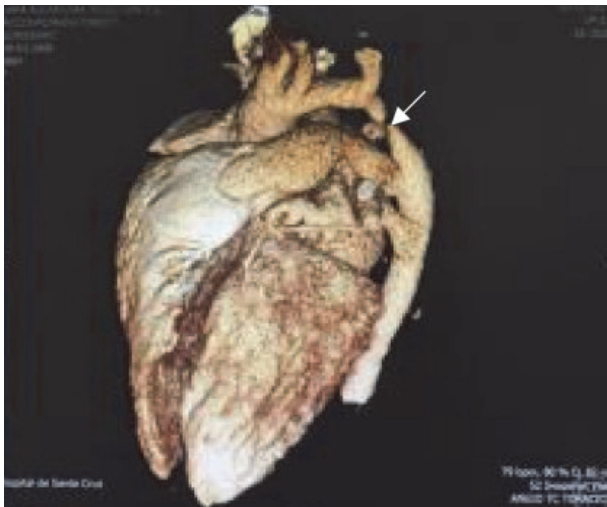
Transthoracic echocardiogram: Tortuous aortic arch from the isthmus region, with evident caliber decrease from the ascending aorta to the distal transverse arch.
